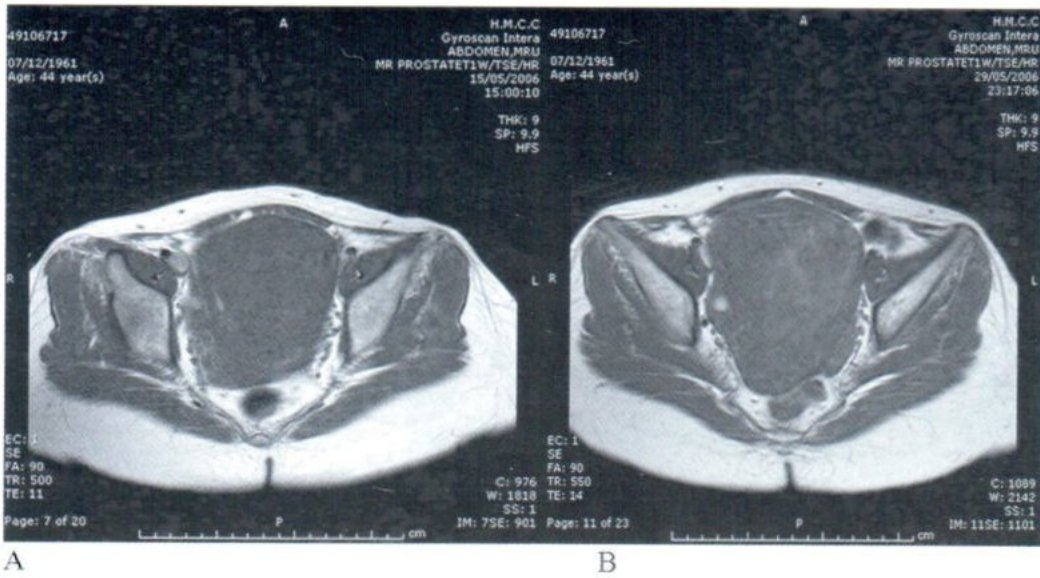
T1-weighted axial image of the uterus. A:Prior to UAE. Large intramural fibroid with isosignal intensity. B:15 days post-UAE image revealed heterogenous increased signal intensity, represents hemorrhagic infarction.
